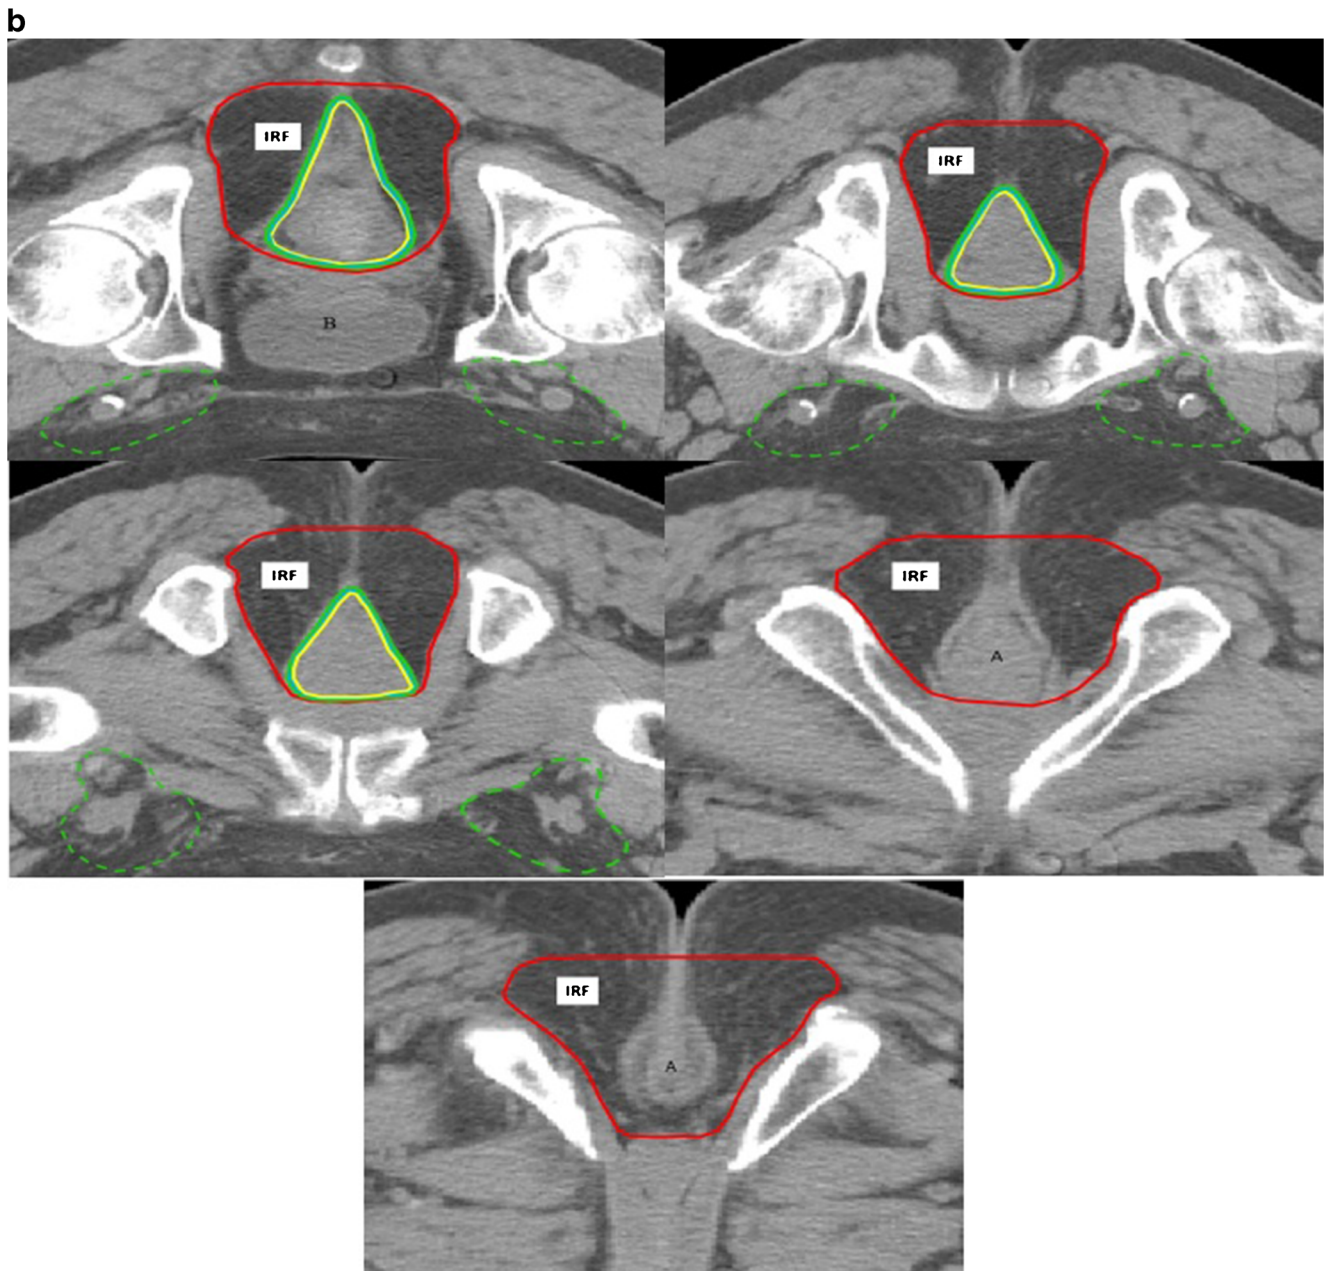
a, b Definition of CTV on axial CT scans are shown: standard contouring (cT3 and/or  $N_{1-2} > 10$  cm above the anal canal) (yellow), expansions in case of ischio-rectal fossa invasion (red); expansion in tumors less than 10 cm from the anal margin (blue); expansion in case of anterior organs infiltration (green); expansion in case of other external
